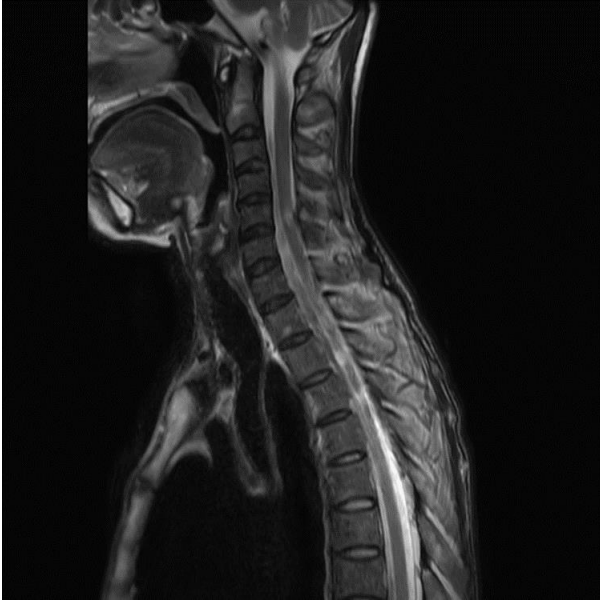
Whole spine MRI - T2 high signal in bilateral posterior and lateral horn of spinal cord, C5 level.
